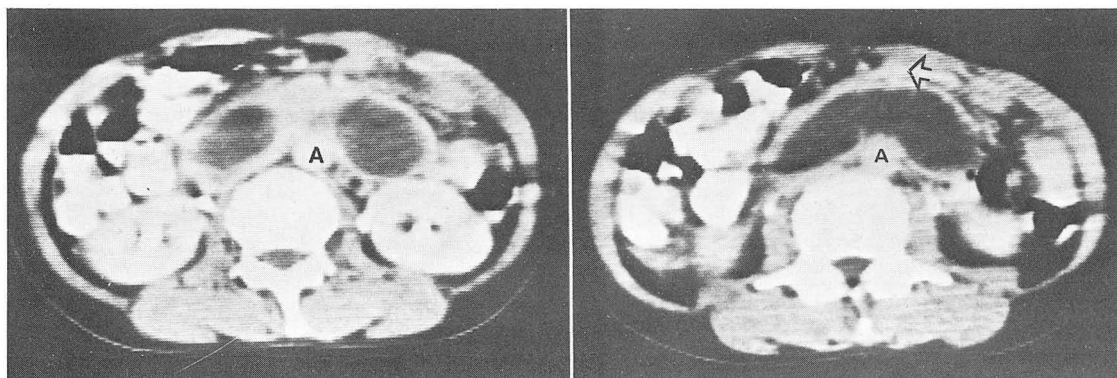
CT scans demonstrated two masses of water density located between abdominal aorta (A) and SMA (Open arrow), marked anterior displacement of the SMA by these masses and continuity of these masses on the slightly caudal section suggestion a U-shaped mass.
